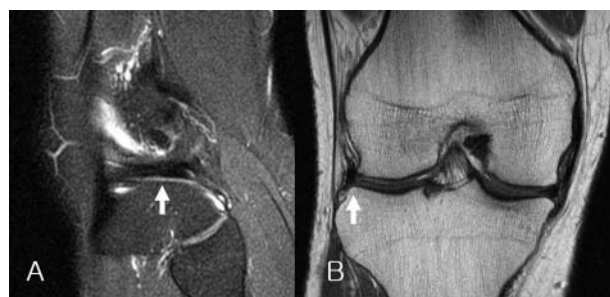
Follow-up MRI at 2.5 years postoperatively in a 19-year-old patient: A, completely healed radial tear (arrow) of the midbody of the lateral meniscus on sagittal view; B, well-visualized midbody (arrow) of the lateral meniscus on coronal view.
